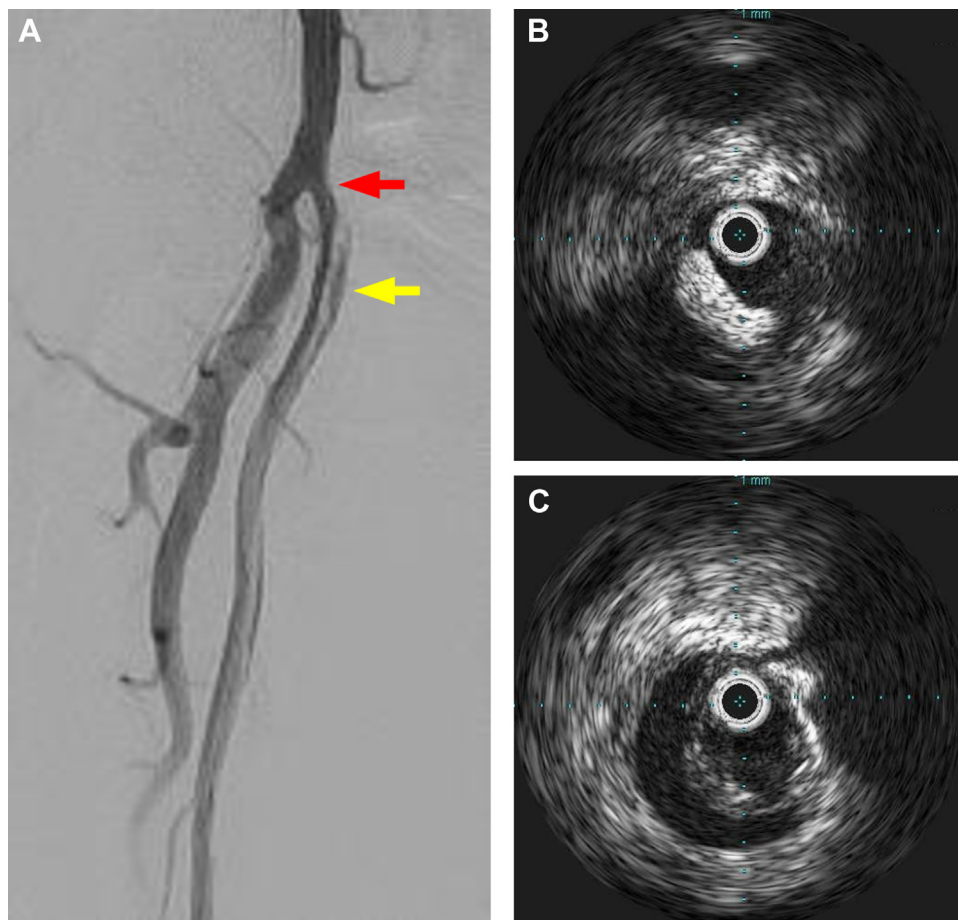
A, Angiography after balloon dilatation. The point of the *red arrow* was the site of the protrusion. Below that point, there were some dissections (*yellow arrow*). B, Intravascular ultrasound (IVUS) image at the *red arrow* (A). The high-density structure was compressed, and the area of the superficial femoral artery (SFA) becomes larger. C, IVUS image at the *yellow arrow* (A). It showed the major dissections.
